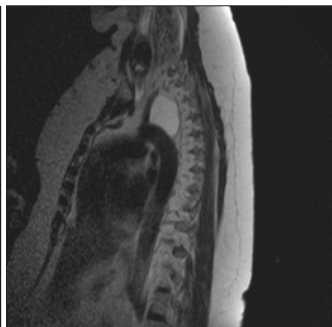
Sagittal T2W MRI of superior mediastinum with well defined cystic lesion of high signal just posterior to left subclavian artery and superior to arch of aorta opposite T3-T4 level about 37 x 26 mm in size.
